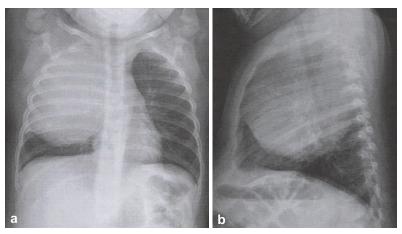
Chest radiography at the hospital revealed the presence of a large, relatively homogeneous opacity, located in the right upper lobe: (a) Anteroposterior view; (b) Profile view.
